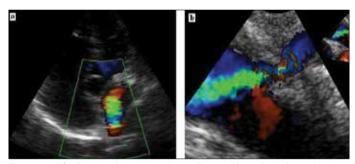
A) 2D transthoracic echocardiographic apical four-chamber view of a color imaging turbulent flow in upper left pulmonary vein in entrance of left atrium. B) 2D transesophageal echocardiography apical four-chamber view of obstruction of left upper pulmonary vein
